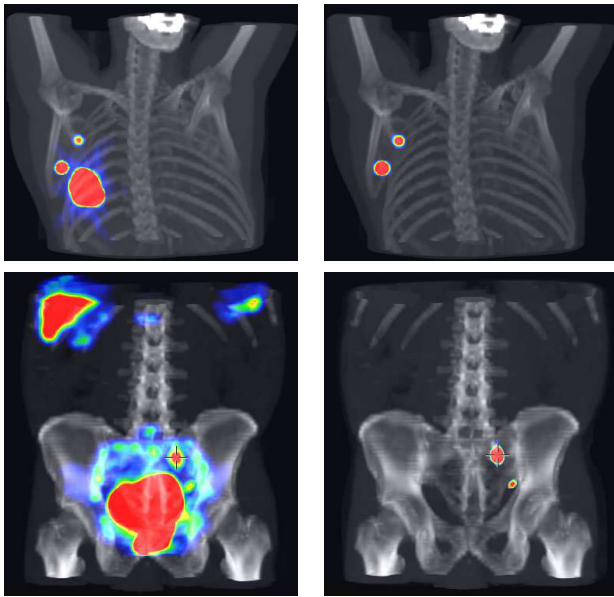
A fused 3D MIP (Maximum Intensity Projection) view of a breast (top) and a prostate (bottom) SPECT-CT case before (left) and after (right) applying our method.
